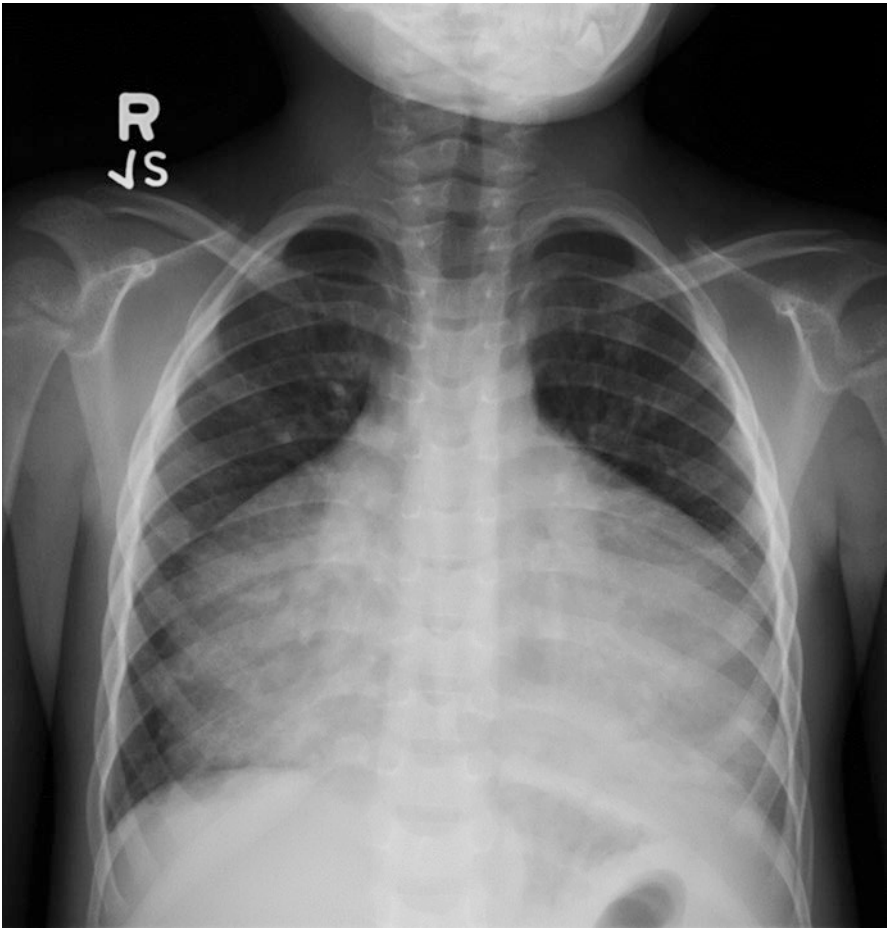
Chest radiograph showing globular enlargement of the cardiac silhouette
